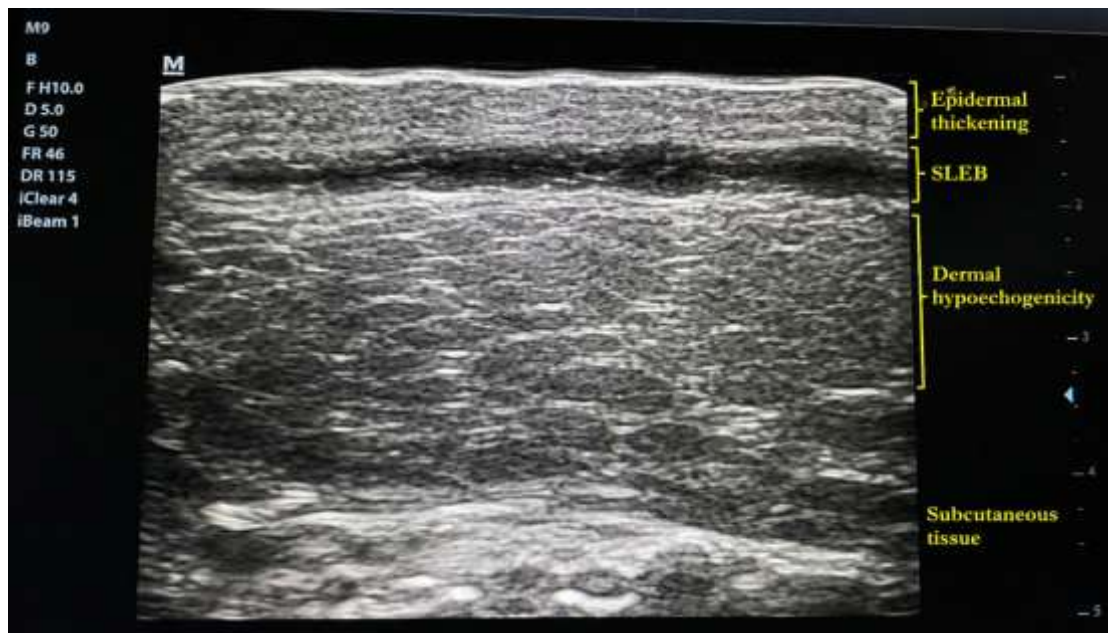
Representative B-mode ultrasound image showing marked epidermal thickening, dermal hypoechogenicity, and SLEB in an active psoriatic plaque.
